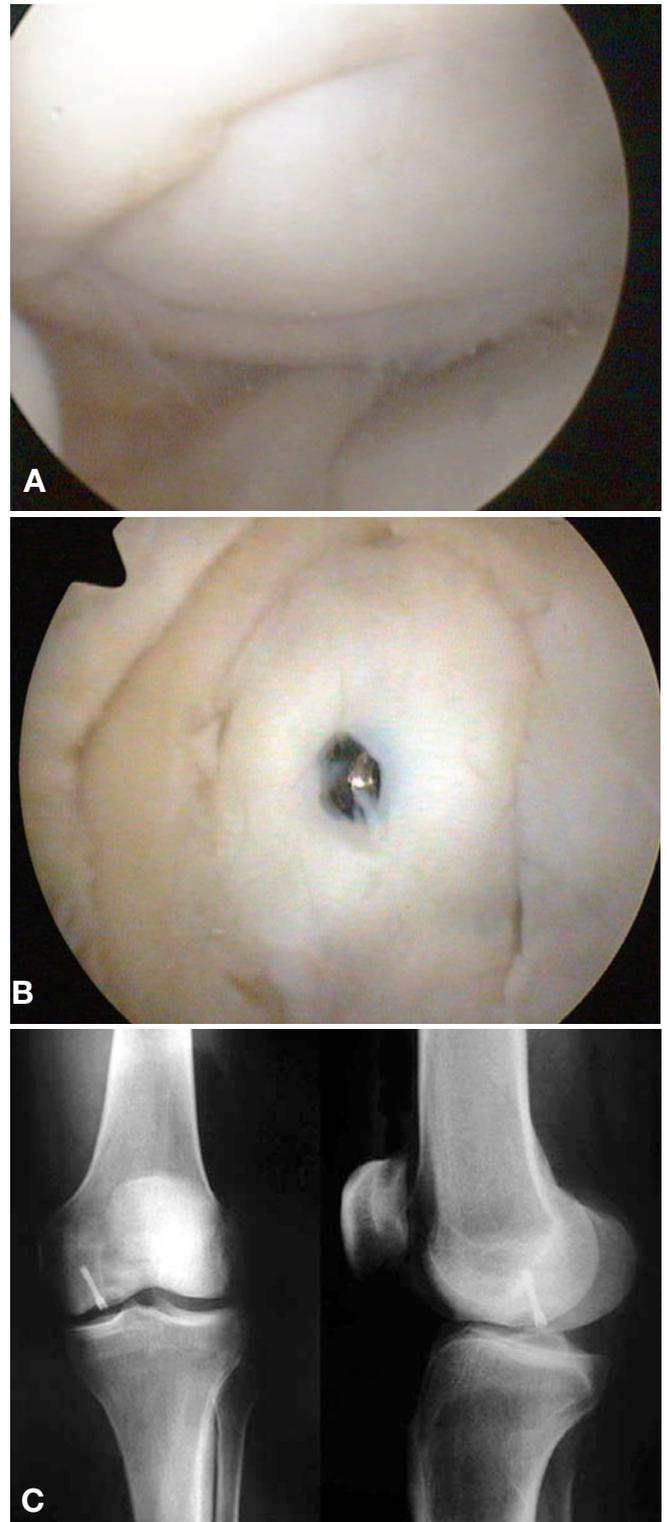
A 26-year-old man with pain in the medial joint of the knee. A, arthroscopic view showing the well-circumscribed lesion on the medial femoral condyle; B, arthroscopic view showing the osteochondral fragment after reposition in the crater and fixation with a Herbert compressive metallic screw; C, immediate postoperative anteroposterior and lateral radiographs showing the osteochondral lesion, which was fixed with a metallic screw.
